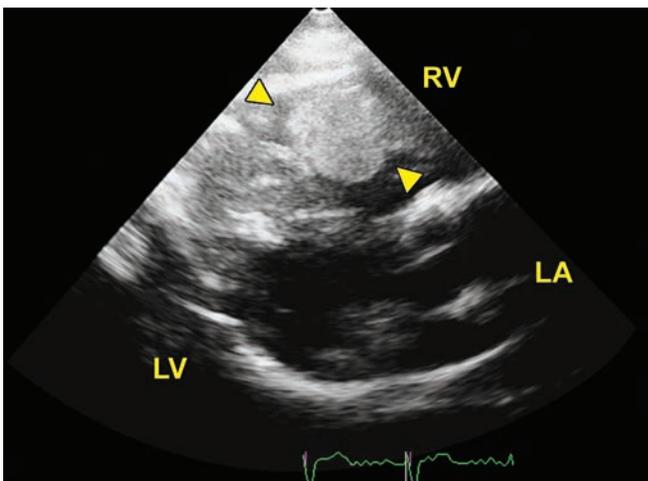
The RV mass (arrowhead) originating from the apex and extending through RV outflow tract in 2D parasternal long-axis view.
